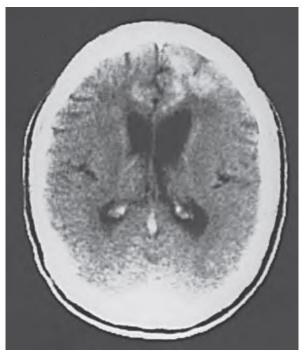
T2-weighted magnetic resonance image depicting extension into the frontal lobe of a patient with *Curvularia* (formerly *Bipolaris*) *hawaiiensis* sinusitis.
